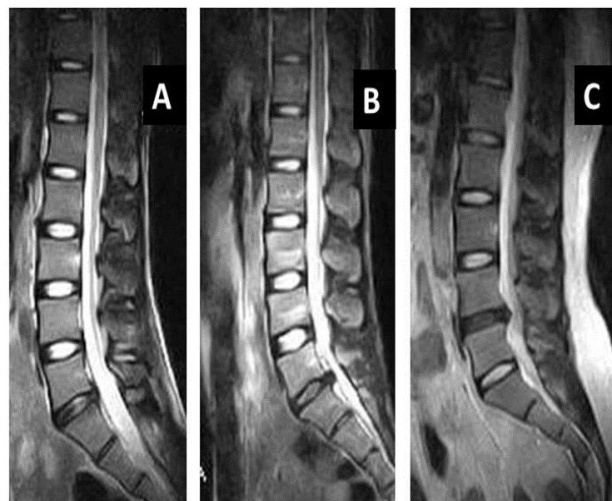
Sagittal view of T2 weighted MRI showing different grades of disc degeneration A) Grade 3 at L5-S1 spinal level B) Grade 3 at L5- S1 with spinal stenosis C) Grade 4
